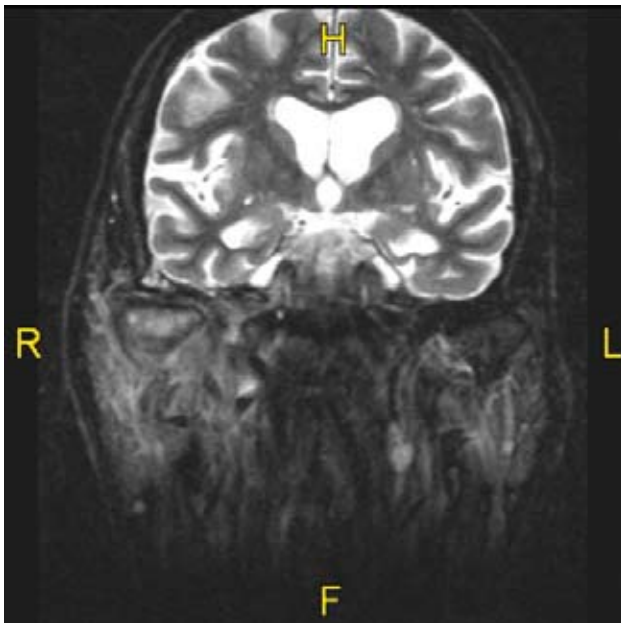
Coronal MRI scan demonstrating osteomyelitis of the right skull base affecting the temporomandibular joint.
